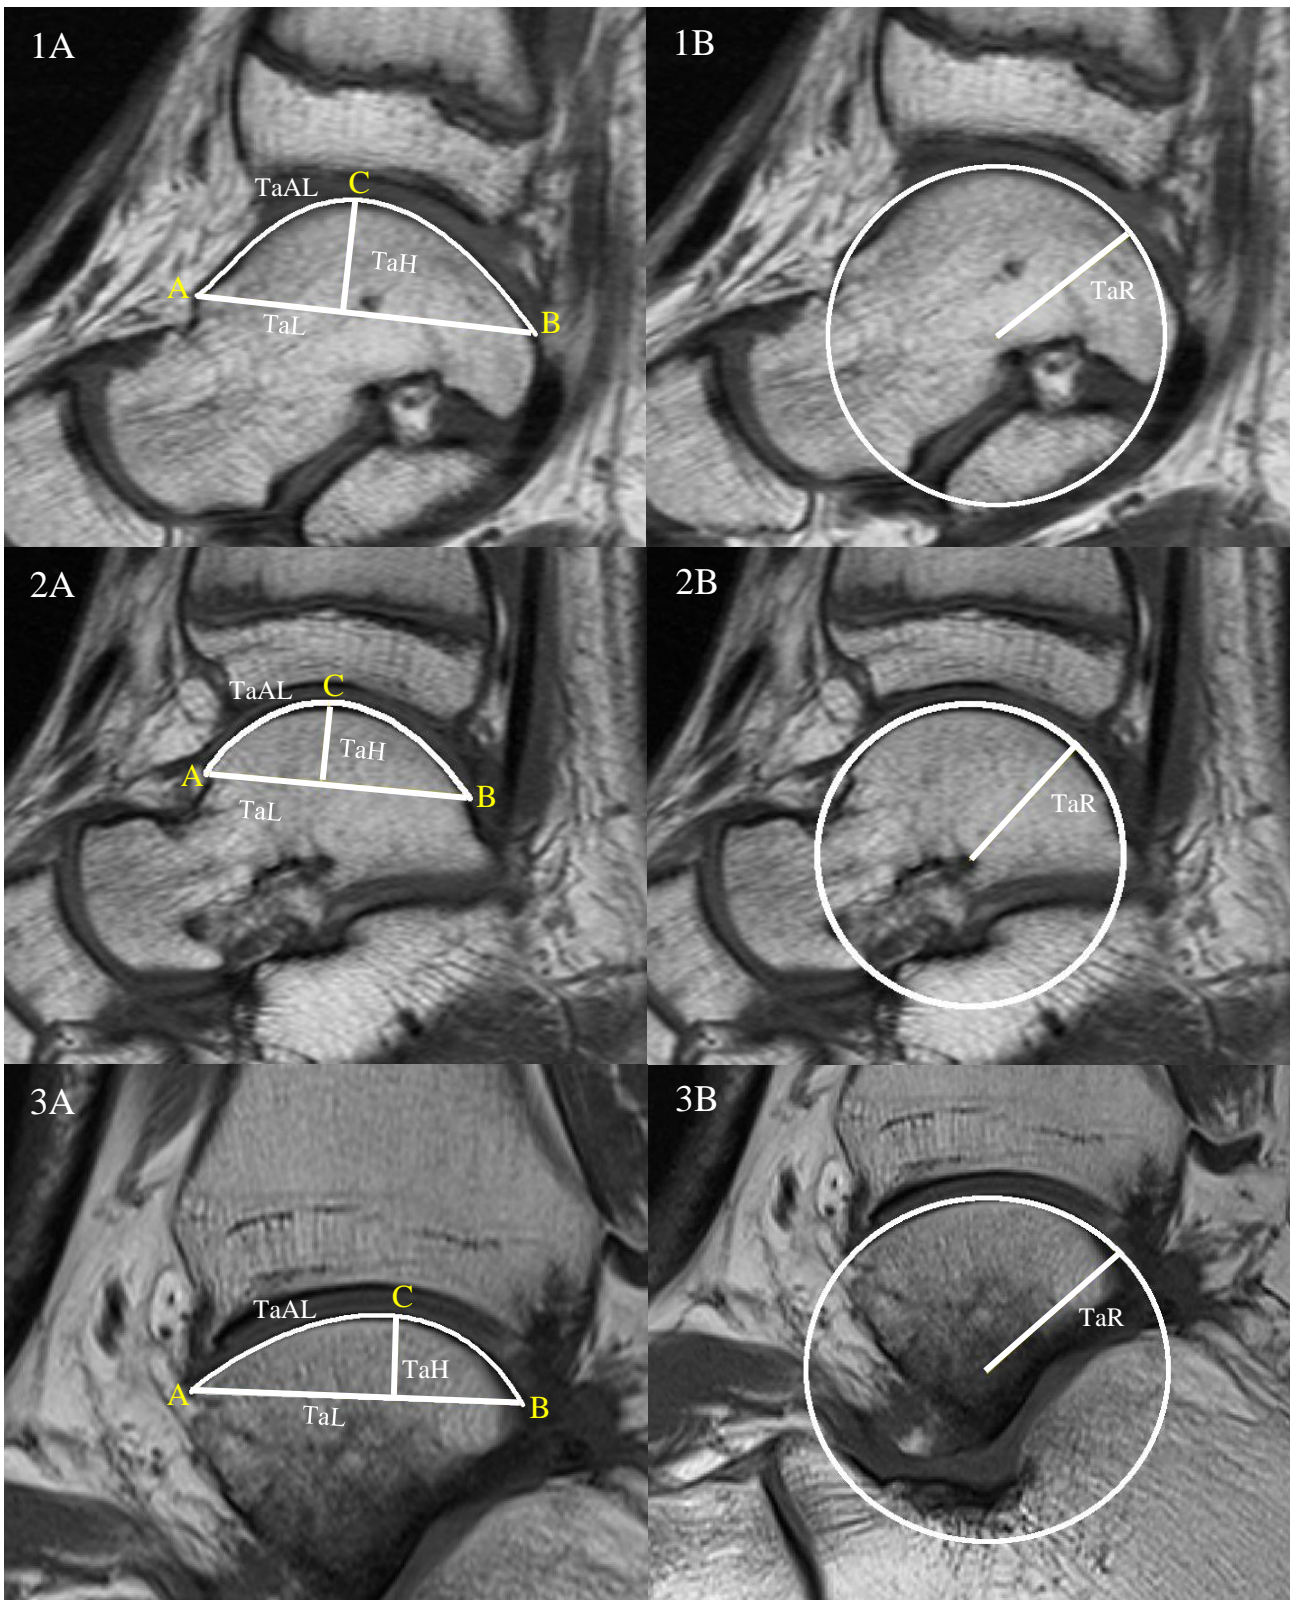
Sagittal MRI of the talus. Images in rows show 1) medial talus, 2) central talus, and 3) lateral talus. Column A shows the fitting of the arc to calculate Trochlear Tali Arc Length (TaAL), Trochlear Tali Length (TaL) and Talus Height (TaH). Column B shows the fitting of a circle to find Trochlear Tali Radius (TaR). Points A, B and C relate to those set out in Table 5.
